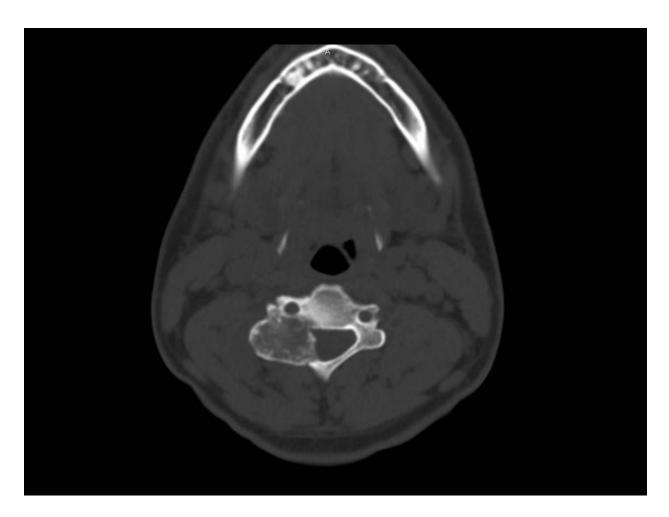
Osteoblastoma is seen on computed tomography in the posterior cervical spine (lamina), demonstrating marked bone expansion with central mineralization.
